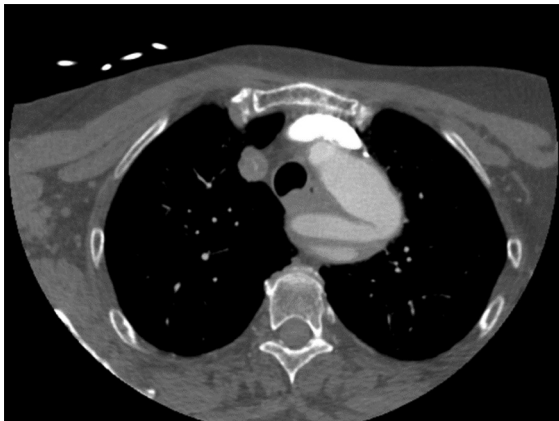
Computed tomography (CT) scan showing aberrant takeoff of the dissected aneurysmatic right subclavian artery.
